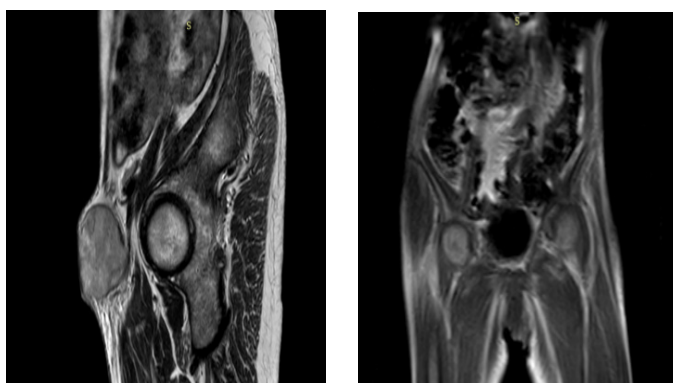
Pelvic MRI. Figure 3 (sagittal
